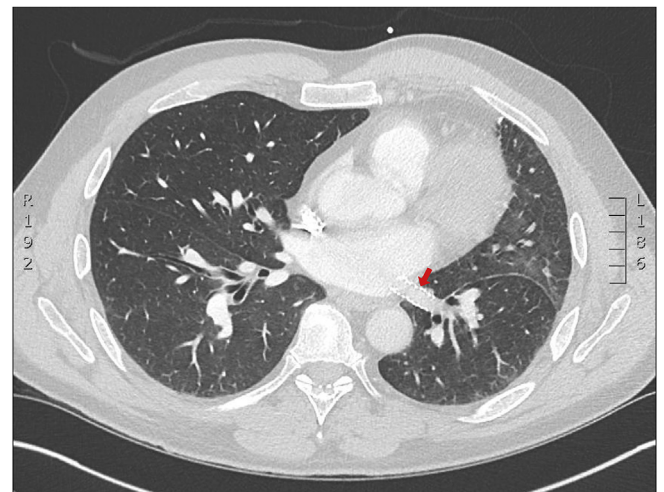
CTA status post PCI of left inferior pulmonary vein.
